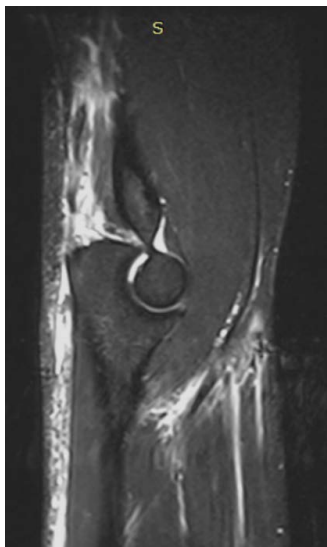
Sagittal T2-weighted image on MRI with high signal between the tendon and the olecranon.
